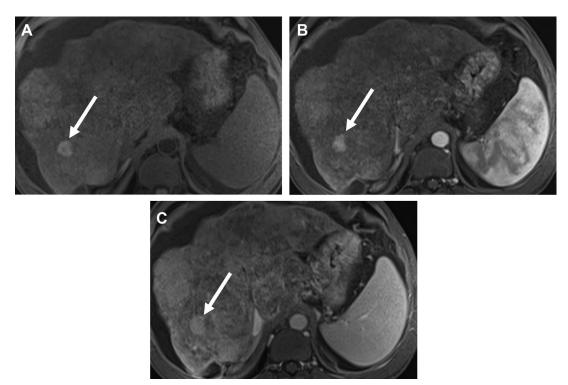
A 40-year-old man with history of chronic Budd–Chiari syndrome. (A). Axial unenhanced T1 FS MR images show hyperintense lesion in segment 8 (*arrow*). Axial T1 FS MR images obtained during hepatic arterial phase (B) and venous phase (C) show persistent hyperenhancement on both phases. The lesions remained stable for 5 years consistent with benignity.
